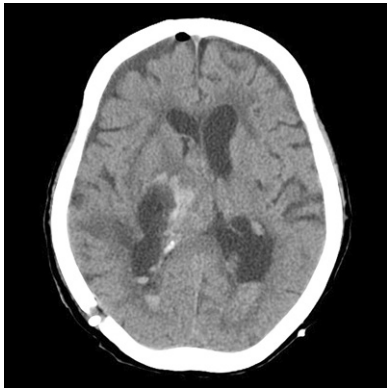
Postoperative axial computed tomographic scan revealing complete evacuation of the hematoma.
